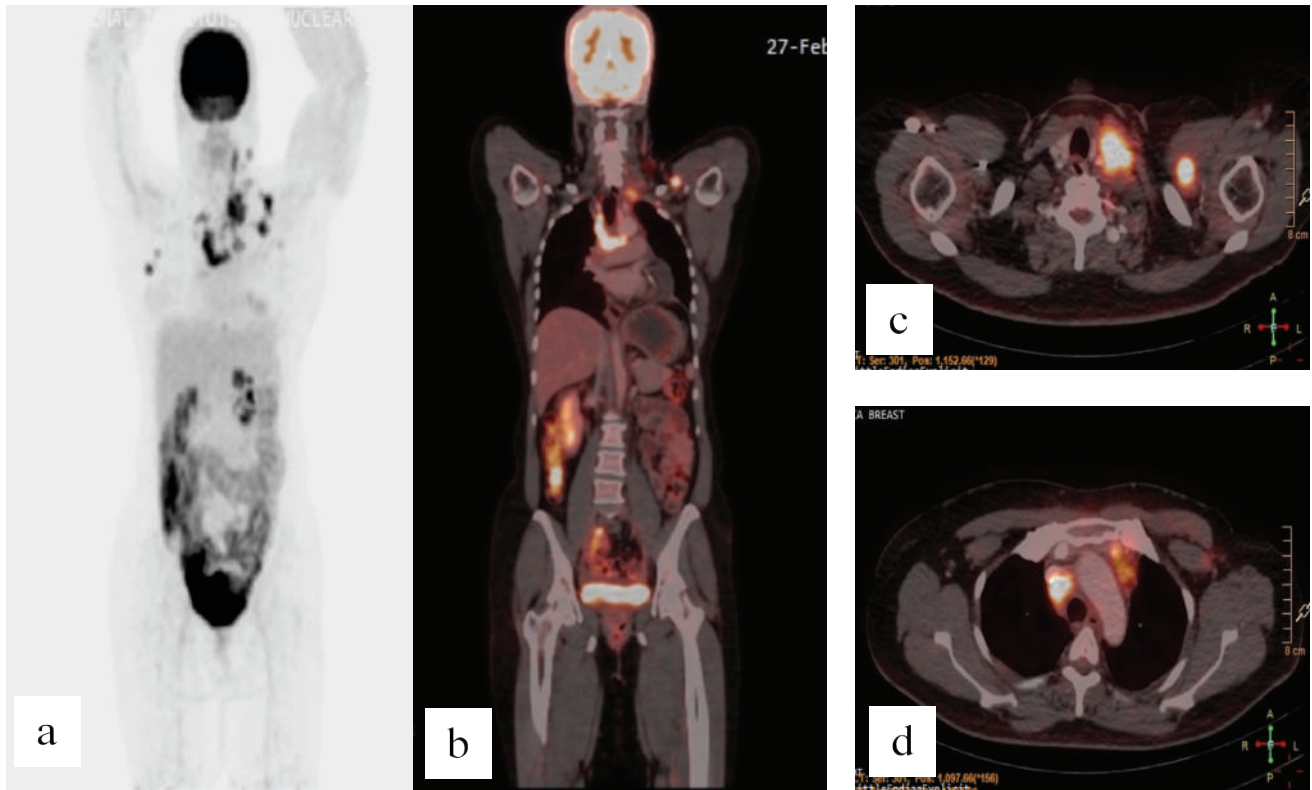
¹⁸F-FDG PET-CT scan image of a 47 years old female with tripple negative breast carcinoma patient. Came for follow up evaluation after 24 months of completion of simple mastectomy with axillary clearance followed by 8 cycles of chemotherapy and 25 fractions of radiotherapy. PET-CT scan showing multiple hypermetabolic mediastinal (b,d) and supreclavicular ymph nodes (b,c) suggesting nodal metastases.
